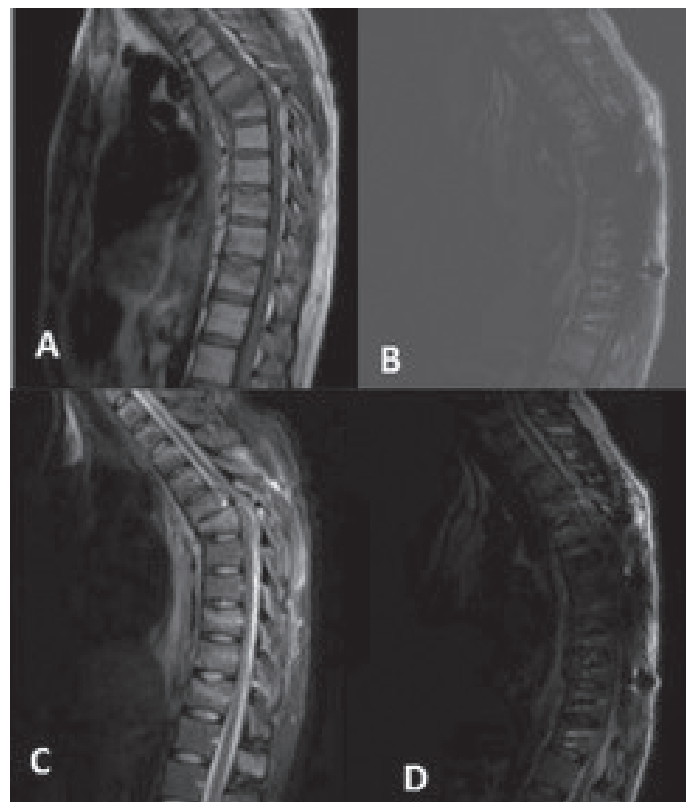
Spinal cord MRI including T1 sequences; (A) postop early, (B) 6 months a.f.i, spinal cord MRI including T2 sequences; (C) post-op early and (D) 6 months a.f.i. showed bilateral myelomalacia
